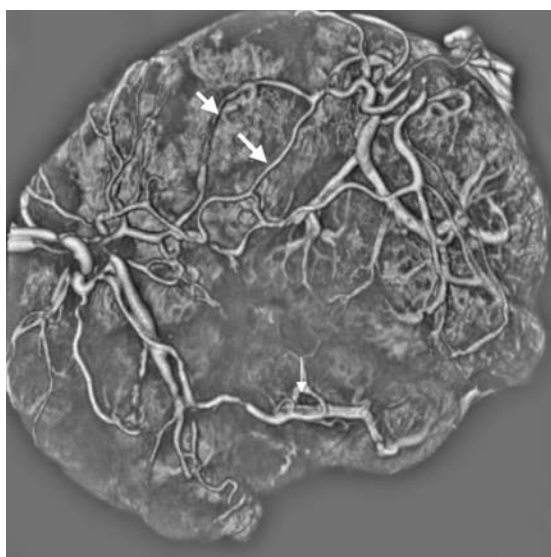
3D reconstruction of a CT angiogram of a monochorionic placenta at term, showing an equal distribution of the injected placental mass and a large arterio-arterial and veno-venous superficial anastomosis (arrows). Photo in collaboration with the Department of Radiology, M. Cannie, UZ Leuven, Belgium.
